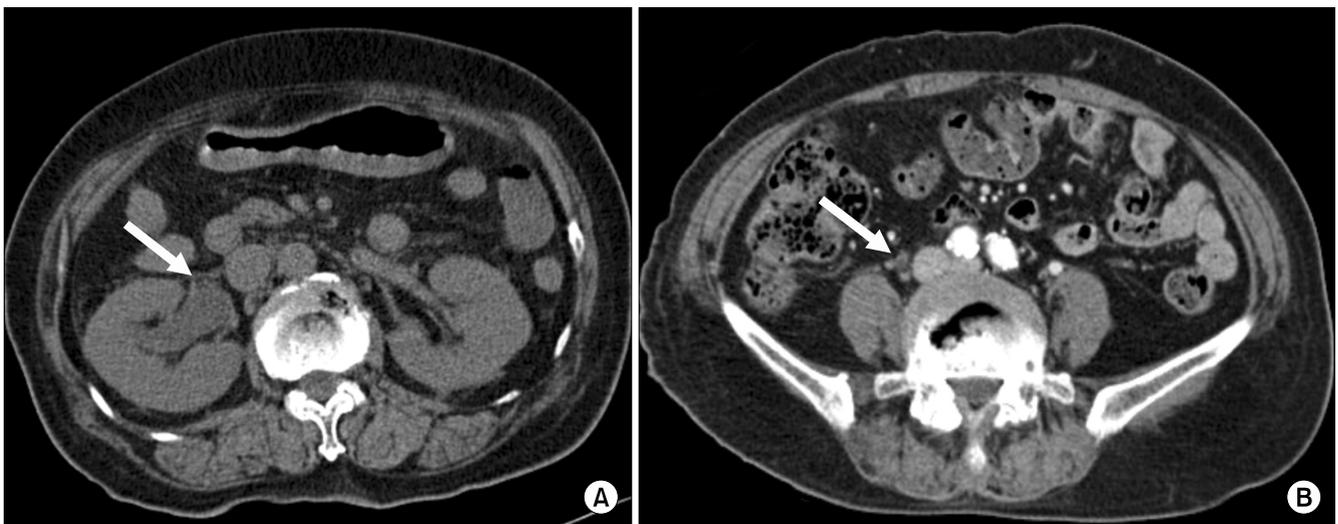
Computed tomography of abdomen. (A) Hydronephroureterosis on right-side (arrow). (B) Abrupt luminal narrowing, without findings of urinary stone, extrinsic compression, or enhancing mass (arrow).
